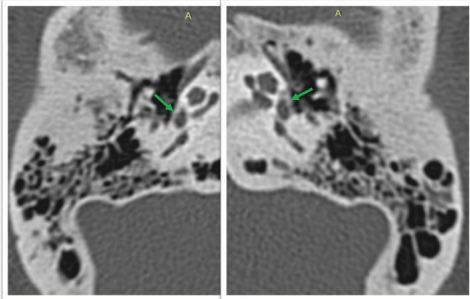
This axial image of a computed tomography (CT) of the temporal bones shows an example of a case of otosclerosis classified as Grade 1. This is a 40-year-old patient with the presence of a reduction in bone density in the ante-fenestram fissula of both the ears (green arrows).
